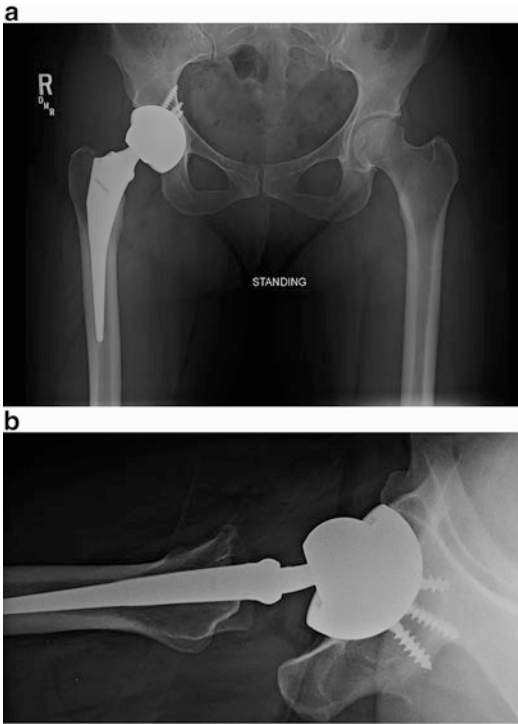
Anteroposterior pelvis (a) and cross-table lateral hip (b) radiographs demonstrating a cementless total hip arthroplasty without signs of radiographic loosening. The acetabular component is in approximately 60° of abduction and 30° of anteversion
